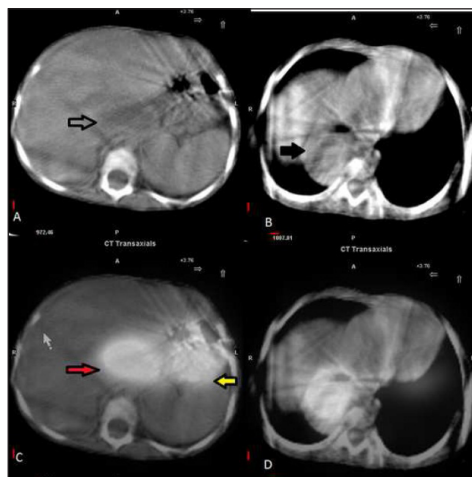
SPECT-CT images reveal (A) hypodense area in the epigastric region with increased tracer uptake as shown by solid orange arrow in image (C). Physiological uptake in the stomach is noted (yellow arrow). Images (B) and (D) show linear area of increased tracer uptake in the thoracic component of the duplication cyst in the posterior mediastinum. The above-mentioned findings localized the presence of Tc-99m pertechnetate (ectopic gastric mucosa) in the thoraco-abdominal cyst.
